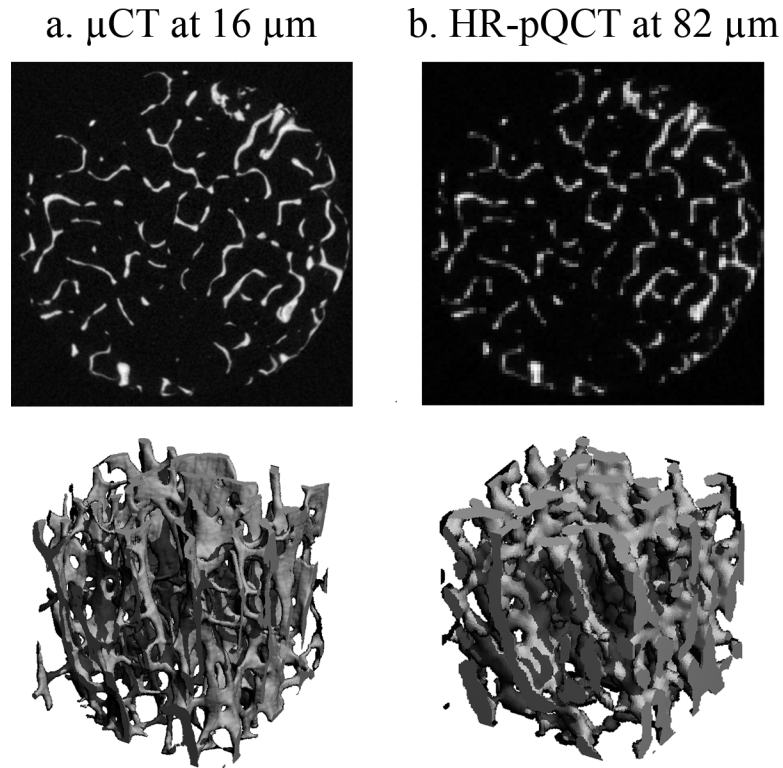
The representative visually matched grayscale cross-sectional images (top) and three-dimensional images (bottom) of human distal tibia imaged using a) μ CT at 16 μ m, and b) HR-pQCT at 82 μ m (equivalent to relative resolution of 1.73 pixels/Tb.Th). The image is highly pixelated causing severe approximation of the fine trabecular structure in the HR-pQCT image.
